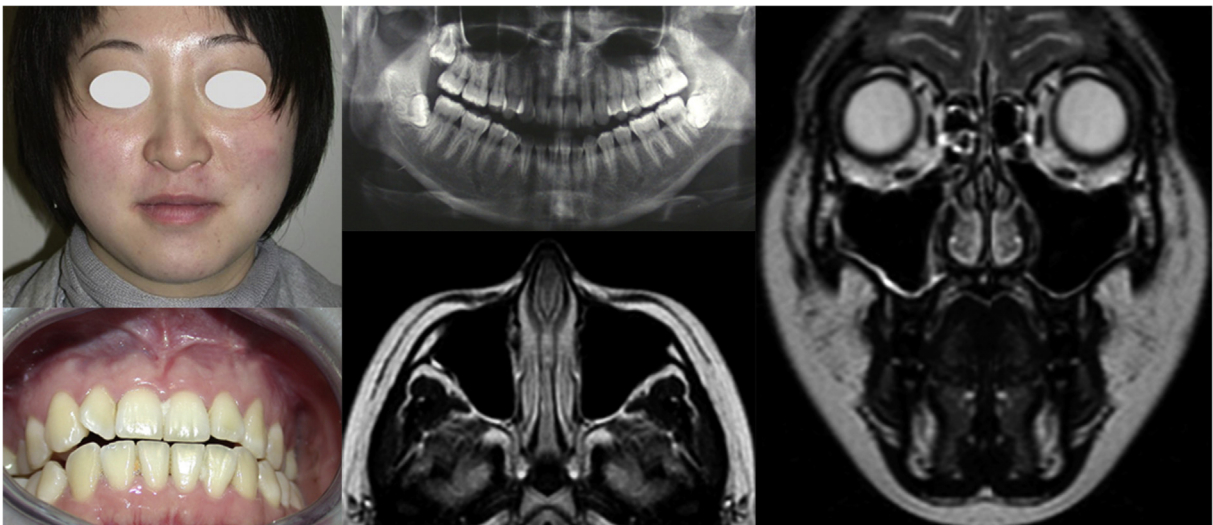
The 5 years clinical and MRI follow-up, showing no signs of relapse.
